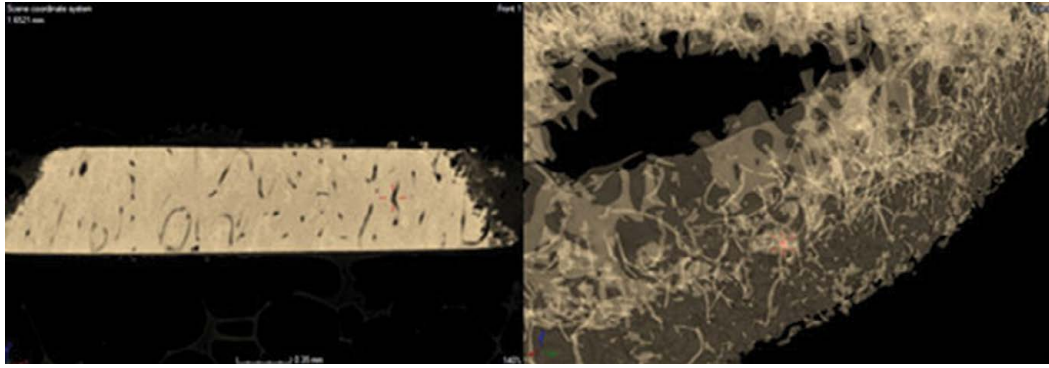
The image of dentinal tubules using micro-computed tomography system 1: 0.035 (v|tome|x m, General Electric-Measurement & Control Solutions, Germany).
